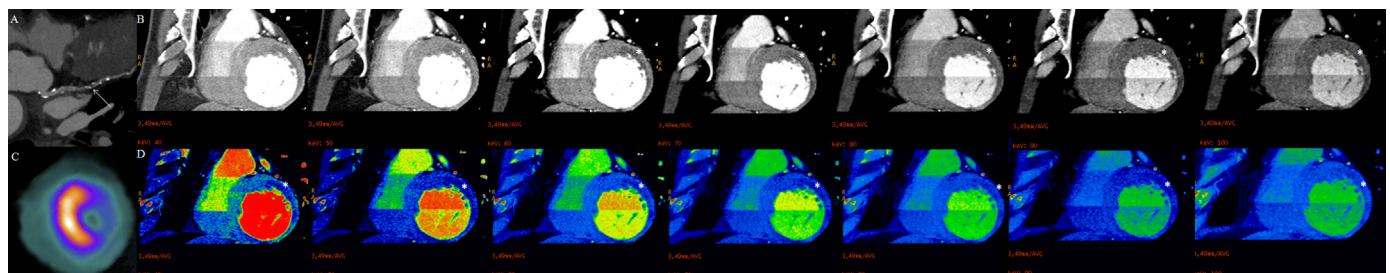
Myocardial perfusion imaging by dual energy CT (DECT) in a 79-year-old male with hypertension and hypercholesterolemia as coronary risk factors, and typical chest pain, referred for myocardial perfusion imaging by single-photon emission computed tomography (SPECT). Curved multiplanar reconstruction showing a severe stenosis at the mid left circumflex artery (arrow, panel A). Monochromatic reconstruction of stress-DECT at 10 keV interval energy levels (panels B, from 40 to 100 keV) and color coded (panels D, from 40 to 100 keV) demonstrate a perfusion defect at the lateral wall that persists at all energy levels. Stress-SPECT (panel C) confirms the findings. Rest of the images (not shown) demonstrate normalization of perfusion defects.
